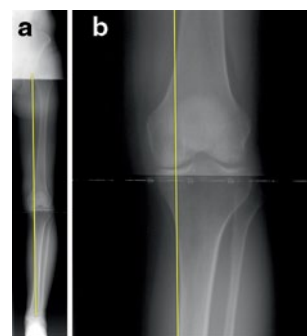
A long-leg radiograph demonstrating a varus weight-bearing axis (a); a close view showing the weight-bearing axis point passing medial to the medial tibial eminence (b)
